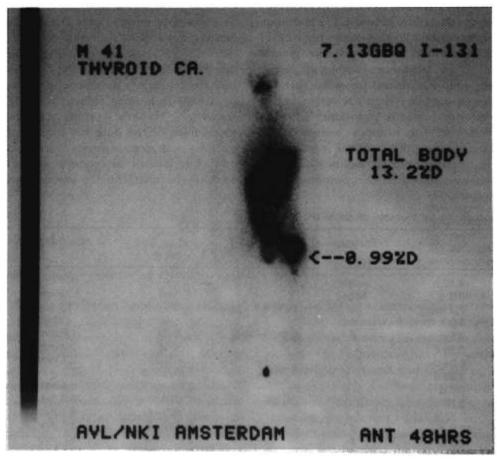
Post-therapeutic total body scintigram 48 h after 7.13 GBq [<sup>131</sup>l]iodide for differentiated thyroid carcinoma metastatic to the proximal left femur.
